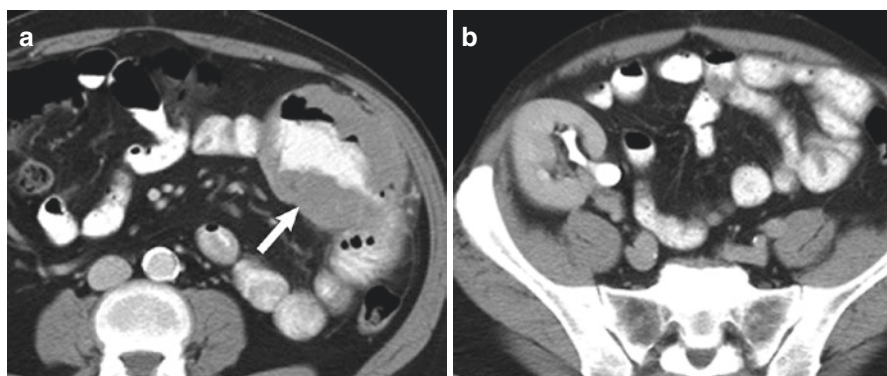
A 60-year-old man status post renal transplant with small bowel PTLD. (a) Contrast-enhanced CT shows marked circumferential small bowel wall thickening with aneurysmal dilation (arrow). Note the oral contrast in the lumen and lack of obstruction. (b) Right lower quadrant renal transplant
